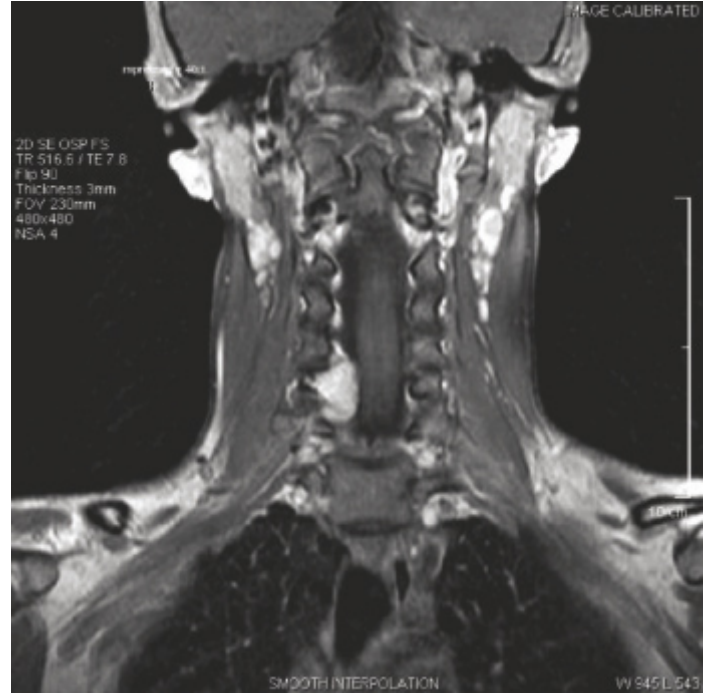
T2-weighted sagittal MRI demonstrating a hyperintense lesion involving the lamina and right lateral mass of C6 extending into the neural foramen.
